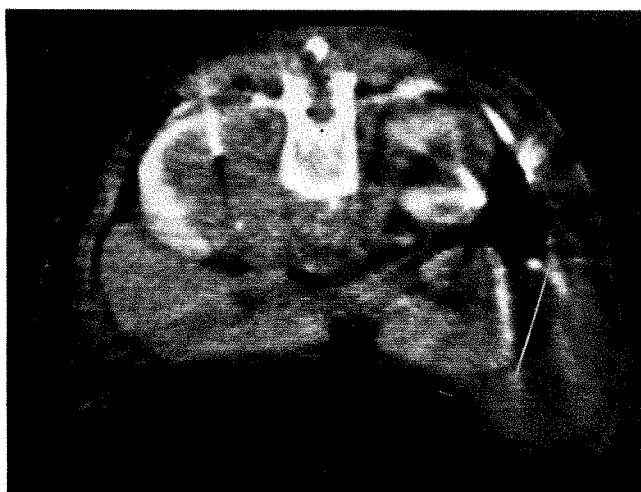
CT scan showing position of needle biopsy.
